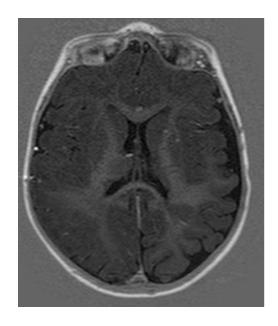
Brain MRI Source: Clinical history of the Metropolitan Hospital
